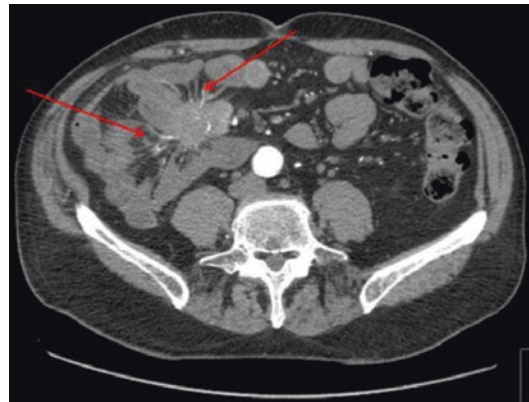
Desmoplastic Reaction and fibrosis of Small bowel mesentery. (Written consent and permission has been obtained from the patient to use these images). Desmoplastic Reaction: CT scan showing desmoplastic reaction from mesenteric metastatic lymph node mass. This patient presented with symptoms of abdominal pain, poor appetite, weight loss and erratic bowel habit. Diagnosed with a small intestinal NET with mesenteric and liver metastases. They were commenced on a somatostatin analogue which initially improved their symptoms. However, over 18 months their symptoms and quality of life worsened, with increased pain and erratic bowel habit. They underwent a small bowel and mesenteric resection for palliation of symptoms with excellent symptomatic benefit
